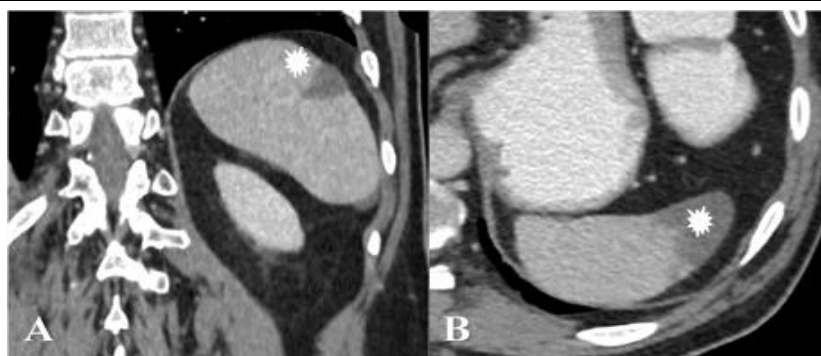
Splenic infarct in a 55-year-old COVID-19 female Coronal and axial contrast-enhanced CT image of the abdomen (A, B) shows a wedge-shaped area of hypodensity reaching splenic capsule at the mid-splenic pole (asterisk).
